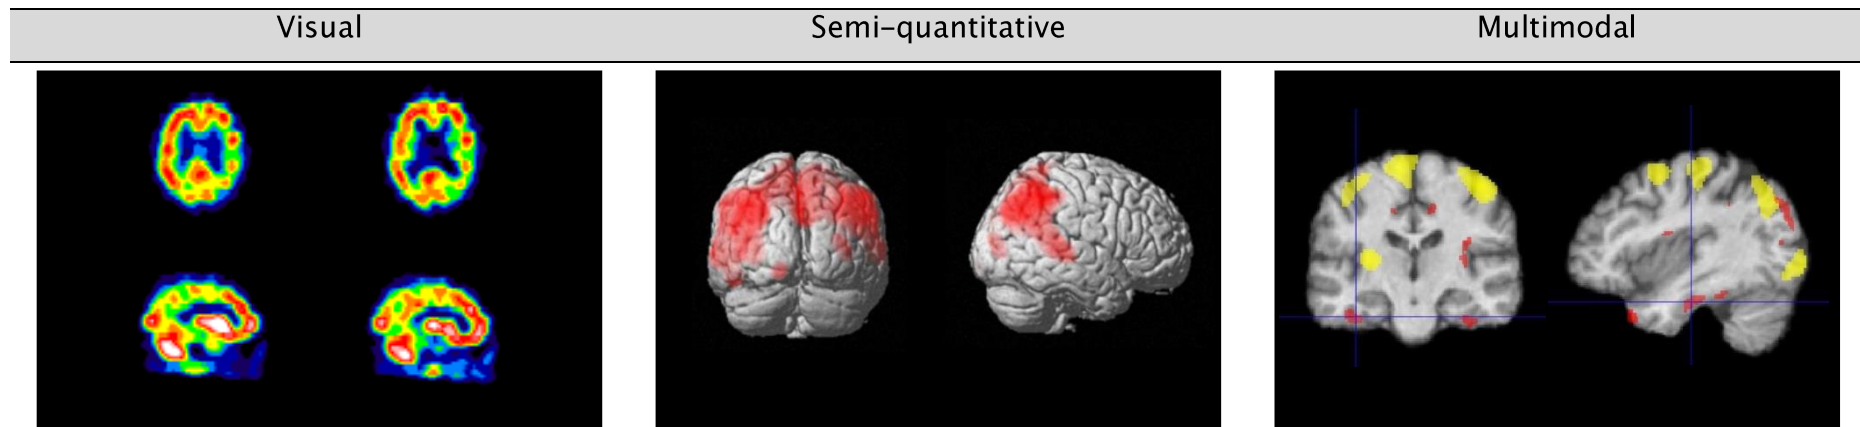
Visual, semi-quantitative and multimodal analysis of perfusion SPECT images
